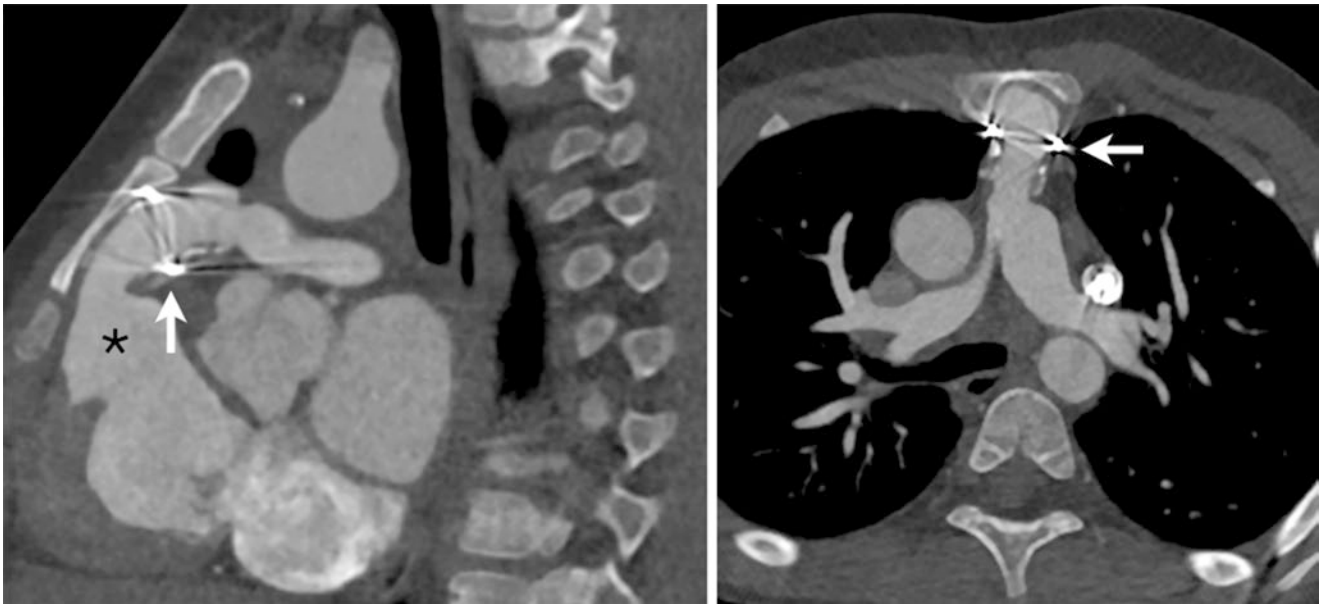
Erosion of a ‘Hancock’ pulmonary conduit through the sternum in a 25-year-old, contrast-enhanced CT. Right image (coronal view); left image (axial view)—‘Hancock’ pulmonary valve metal ring artefact (arrow), right ventricular outflow tract (*). Note the proximal right pulmonary artery narrowing in the right image
